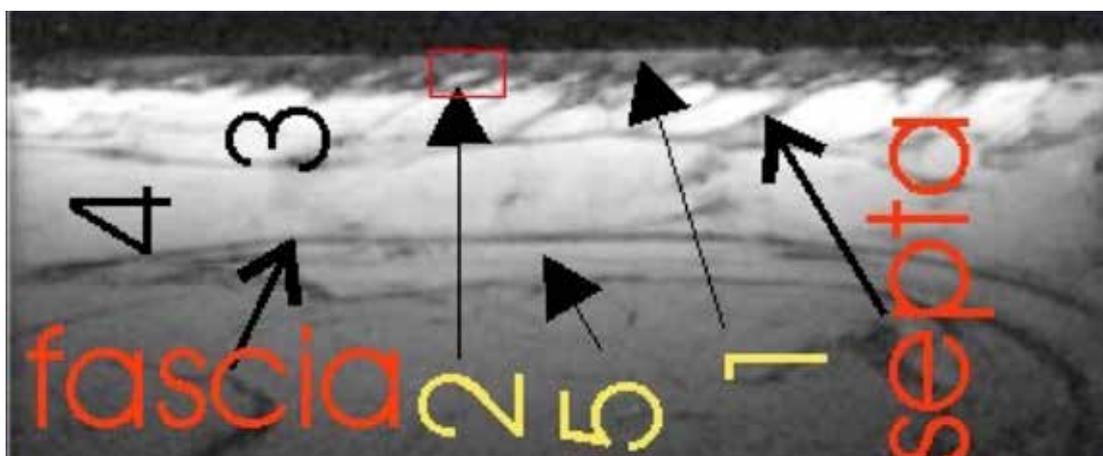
Figure 2: Skin MRI, where Number 1 corresponds to the dermis, Number 2 corresponds to the small adipose papilla towards the dermis, Number 3 corresponds to the hypodermis showing fibrous septa and Numbers 4 and 5 correspond to the subcutaneous cell tissue. Source: Mirrashed F. et al., 2004.⁶
